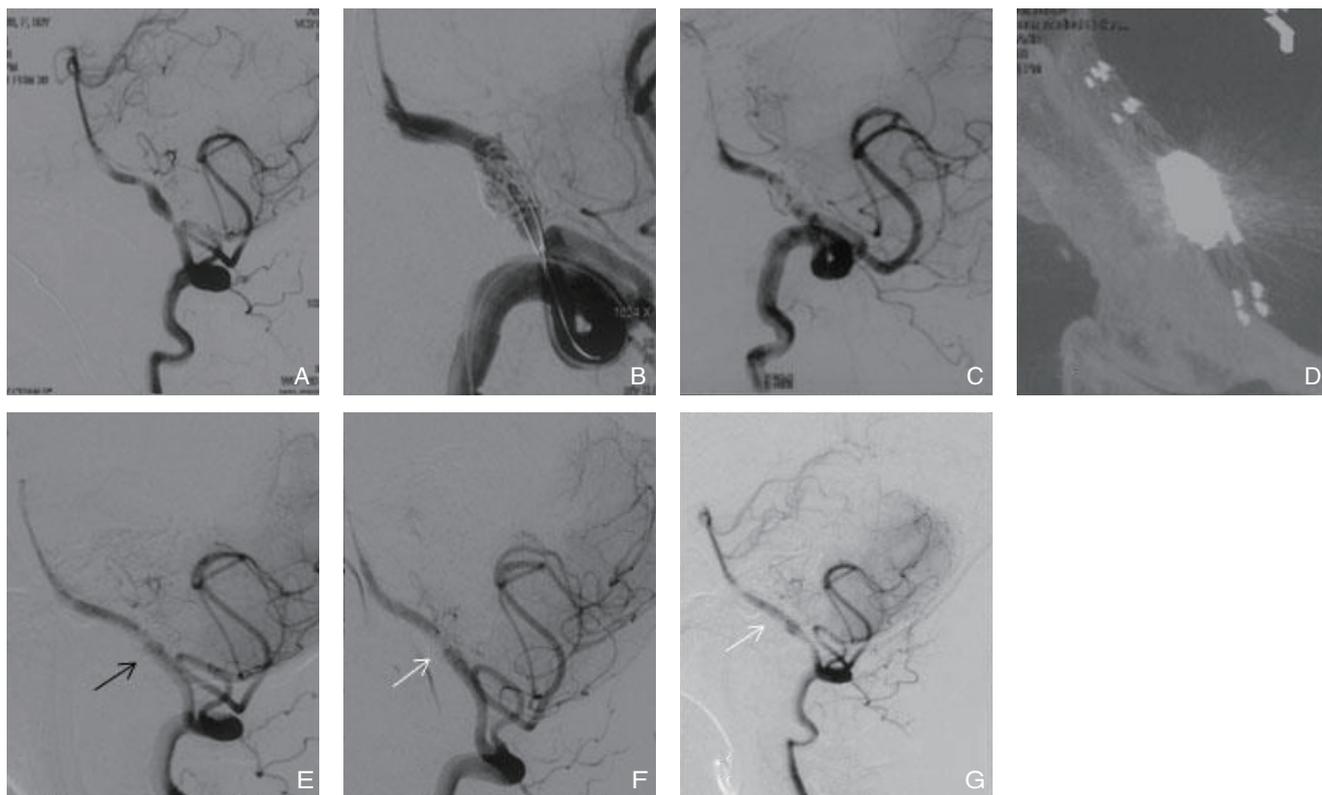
多支架辅助弹簧圈栓塞 A: 病变受累位置有穿支发出; B: 半释放技术填塞动脉瘤, 保护穿支; C: 双支架辅助弹簧圈栓塞后, 动脉瘤不显影, 穿支显影, 血管较术前变直; D: Dyn CT 显示双支架辅助弹簧圈; E: 术后 18 h 出现意识障碍, DSA 复查见穿支不显影 (黑箭头); F: 术中溶栓患者意识恢复, 穿支再次显示 (白箭头); G: 复查血管重塑良好穿支存在 (白箭头)
